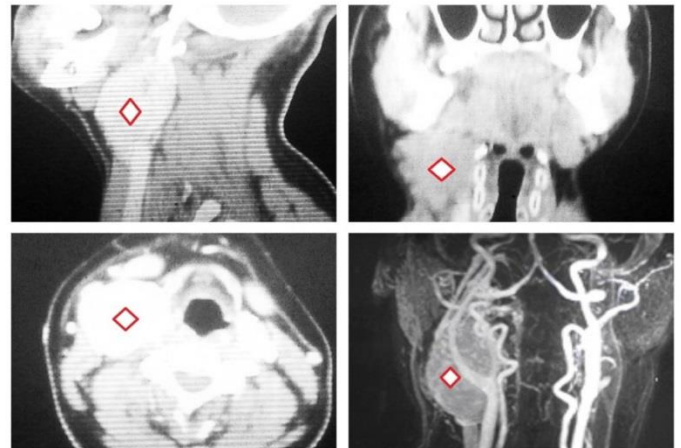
The classic carotid body tumor is located within the carotid bifurcation in the infrahyoid neck and is not in immediate proximity to the PPS. They enhance intensely on CT and have flow voids. Flow voids are diagnostic of paragangliomas.
